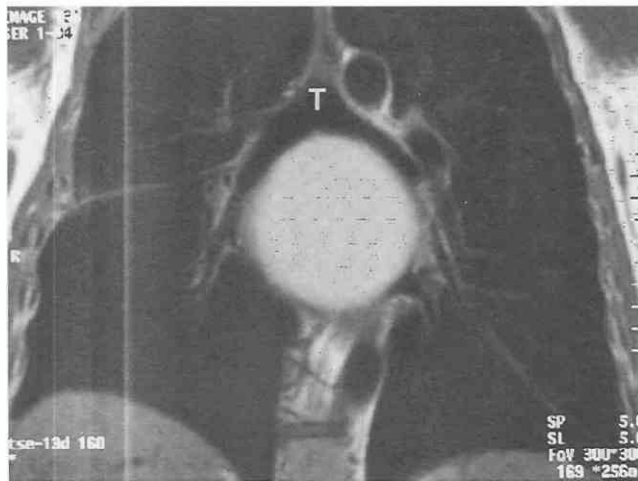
Bronchogenic cyst. Coronal T1-weighted MRI shows a subcarinal mass with high signal intensity. Both main bronchi are displaced. The subcarinal location is typical for a bronchogenic cyst. T, trachea.
